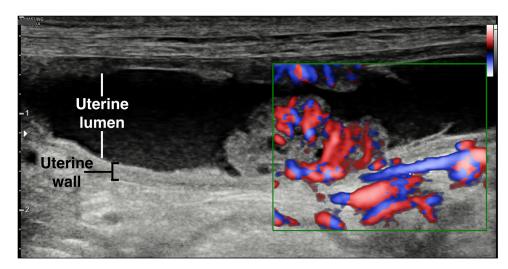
Longitudinal ultrasonographic image of the right uterine horn, with directional power Doppler display (green box). Note the hypervascular, focal florid thickening of the uterine wall protruding into the uterine lumen, which is distended with hypoechoic material
